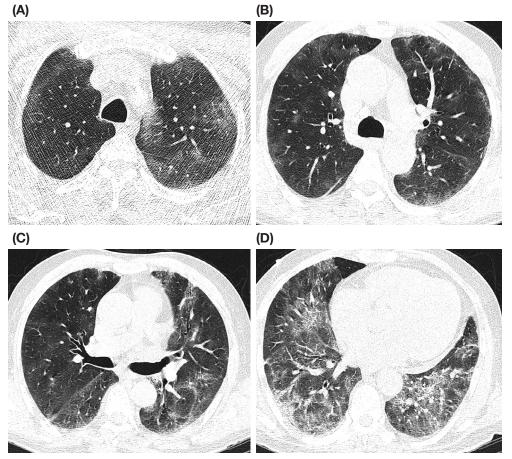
A 62-year-old, non-diabetic man without heart failure, hospitalized with moderate disease at presentation, shows in his first-day in-hospital CT scan extensive lung parenchymal involvement, mainly GGO with minimal consolidation (A-D): CTSS1= 17/24, CTSS2= 32/48, CTSS3= 14/20, CTSS4= 19/25, CTSS5= 22/30, CTSS6= 18/20, CTSS7= 27/40. He was admitted to the ward (moderate disease at triage), admitted to ICU after 5days (severe outcome) and was discharged after 12 days in-hospital stay without intubation.
